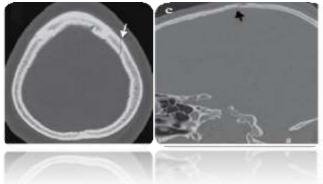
Cuts CT scan in window bone showing a doorframe.
